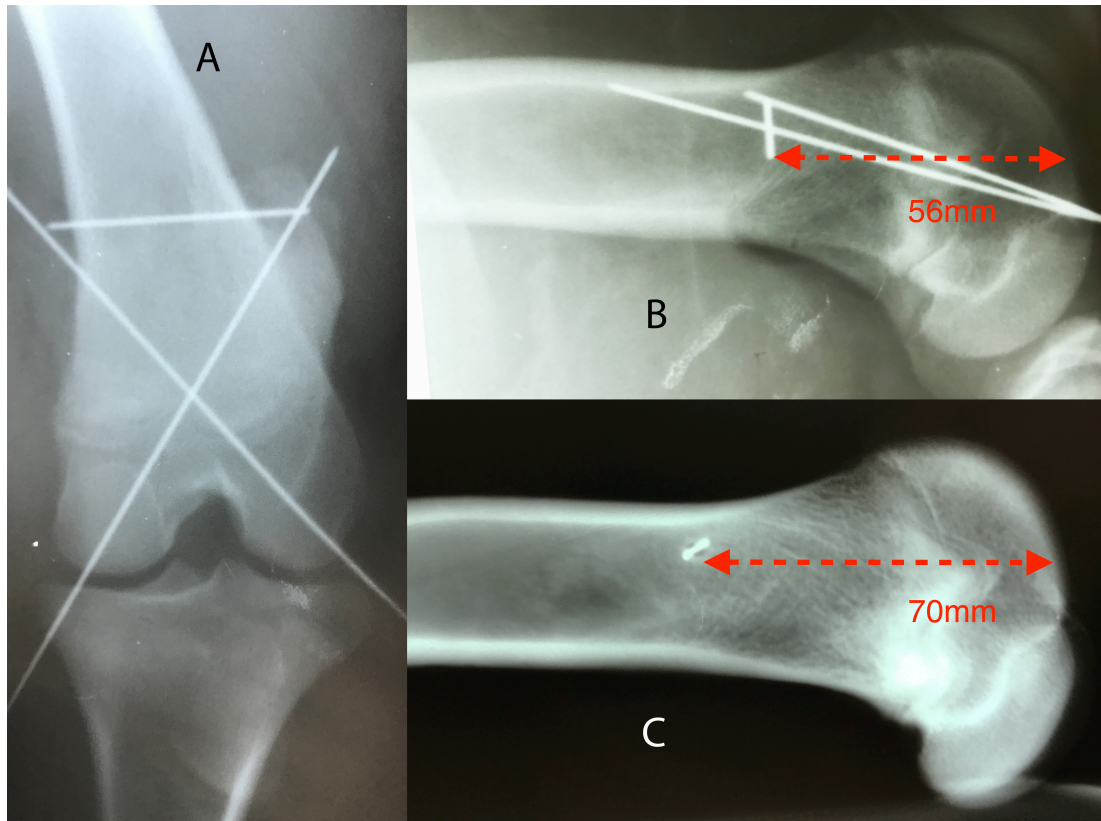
Growth measurement reference wire. (A) Intra-operative anteroposterior radiograph demonstrating the transverse reference wire in sample S11. The crossed wires are the 1.1mm guidewires required for the placement of a Helical Nail. (B) Intra-operative lateral radiograph with the reference wire proximal to the physis, red line denotes length measurement. (C) 6 month lateral radiograph of the same femur. The red dotted lines denotes the length measurements.
